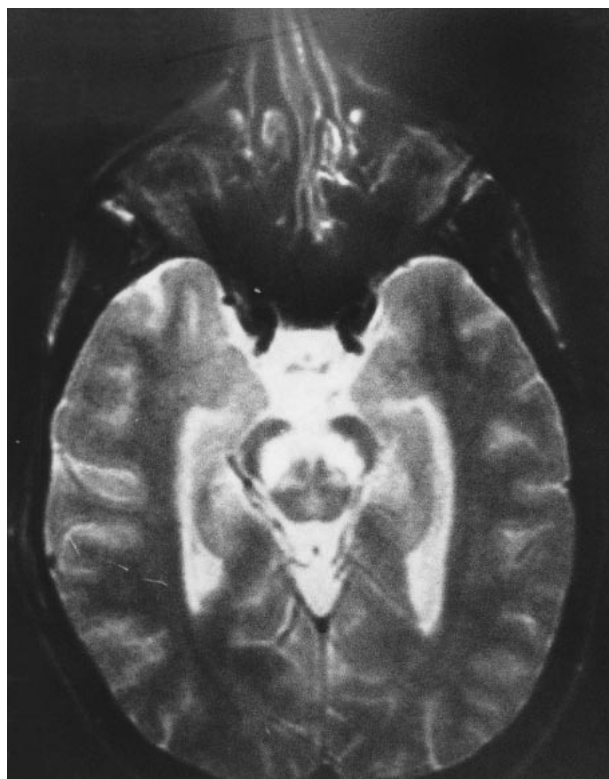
Cranial, axial, T₂-weighted MR image shows hyperintense signal changes in the substantia nigra in a patient with JE.
